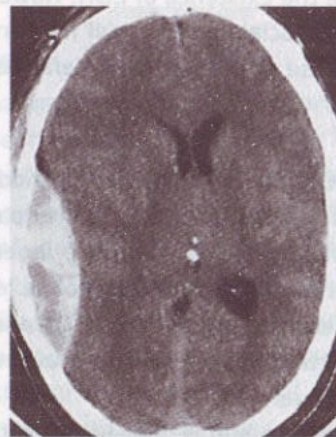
Characteristic CT scan of extradural haematoma
